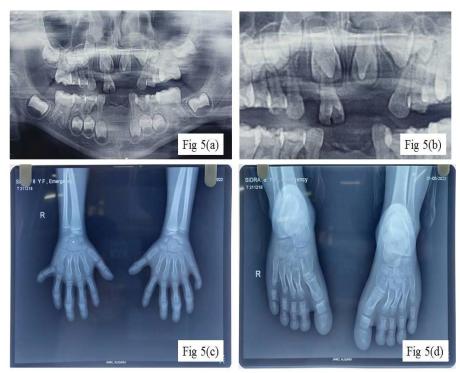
(a): OPG showing multiple missing teeth, Fig 5(b) showing Talon cusps of 11 and 21, Fig 5(c) and 5(d) showing radiographs of hands and feet.
